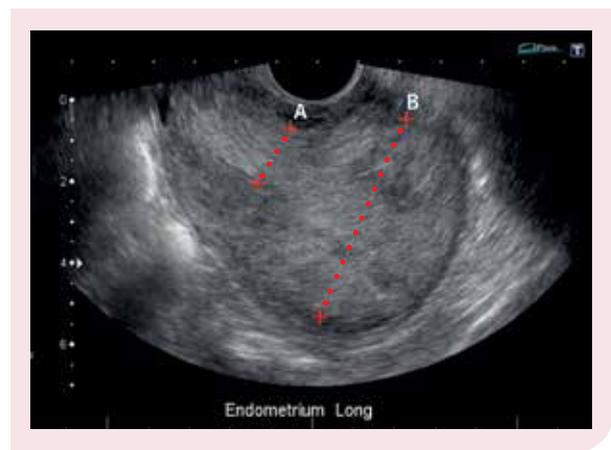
Sagittal ultrasound of the uterus showing irregular endometrial thickening caused by carcinoma. Thinning of the myometrium suggests myometrial invasion by carcinoma (A = lower uterine segment; B = uterine fundus).
